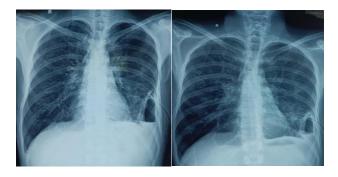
Serial chest radiographs on streptomycin day 8 (ICD day 19) and streptomycin day 17 (ICD day 27).
